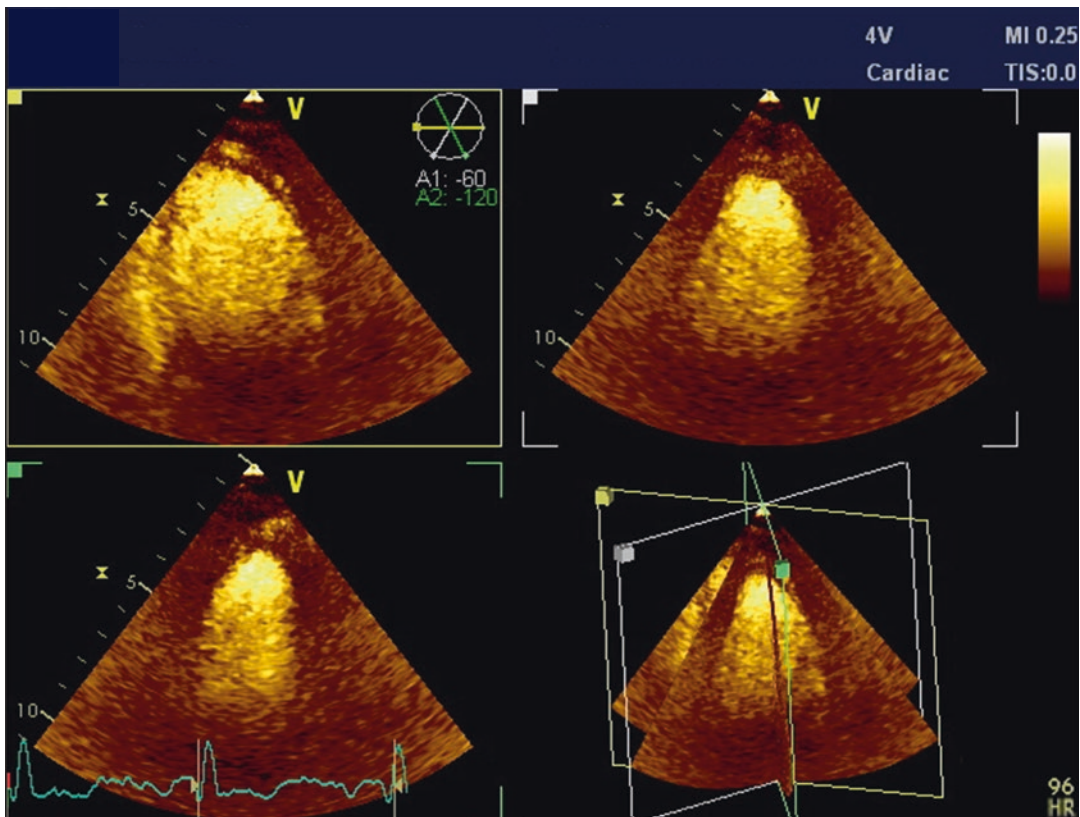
3D LVEF with echocardiographic contrast enhancement
